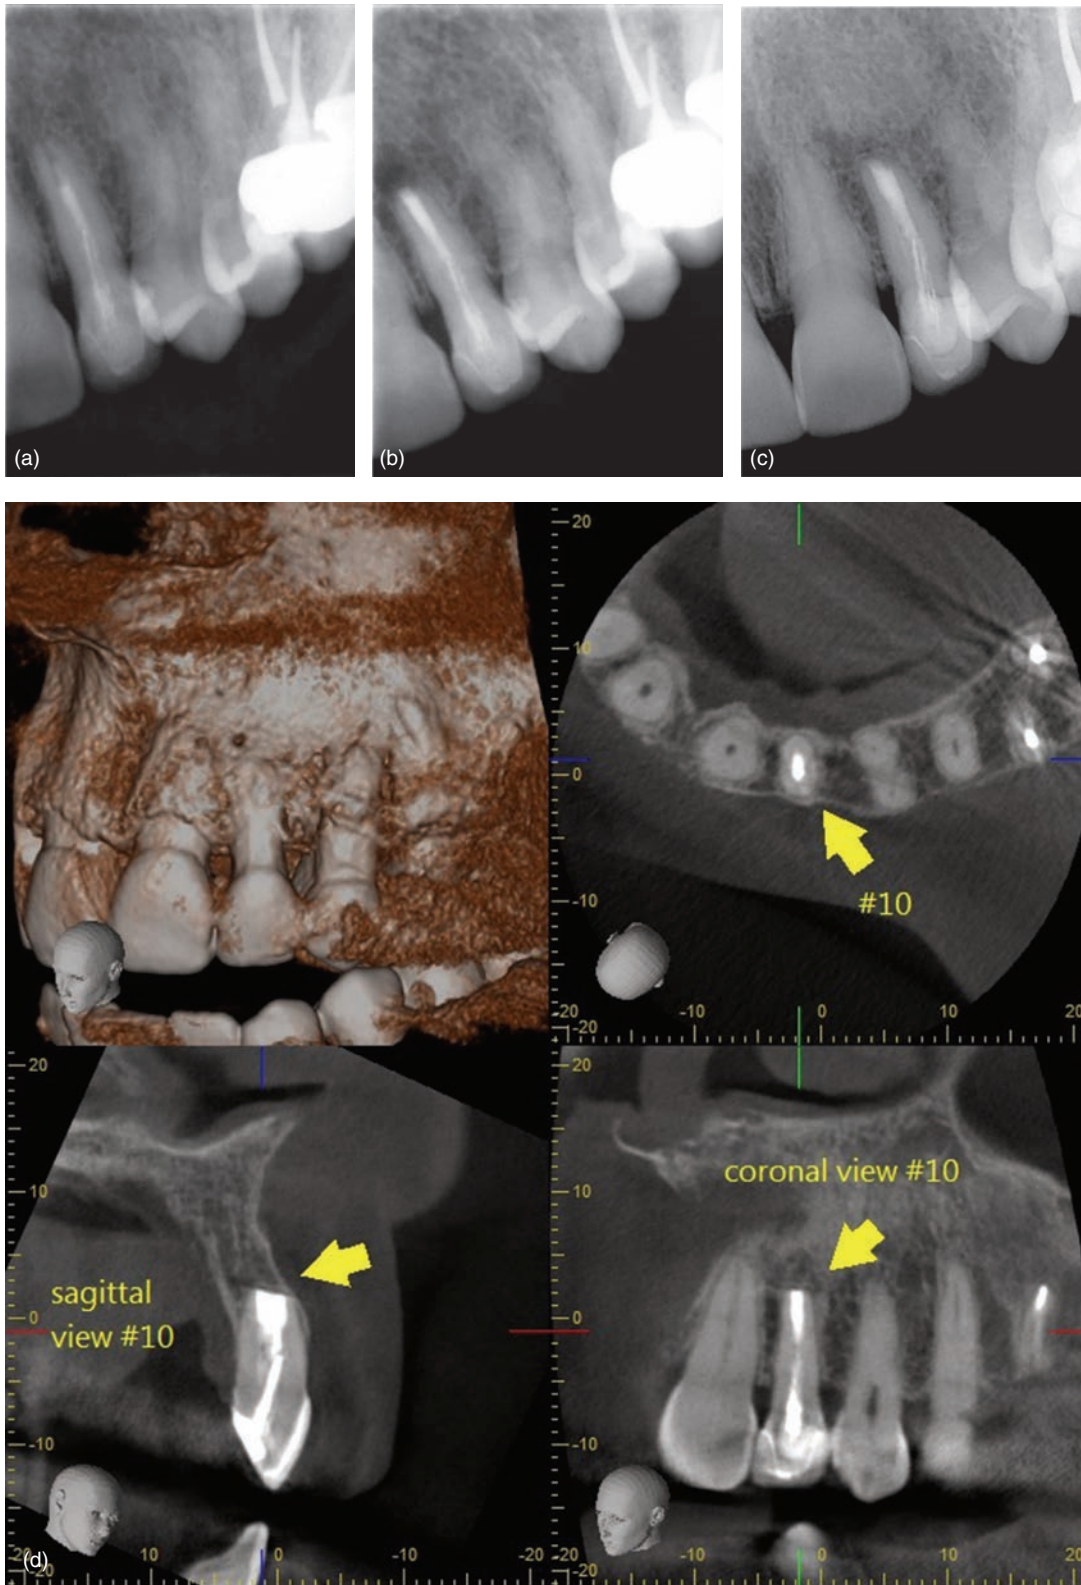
Symptomatic, previously treated maxillary lateral incisor. (a) Due to a long post and well-fitting crown, surgical treatment was planned. (b) Postsurgical radiograph showing root resection and root end filling. (c) A 5.5 year follow-up radiograph. (d) A 5.5 year CBCT shows complete apical and cortical bone healing and reconstitution of PDL.
